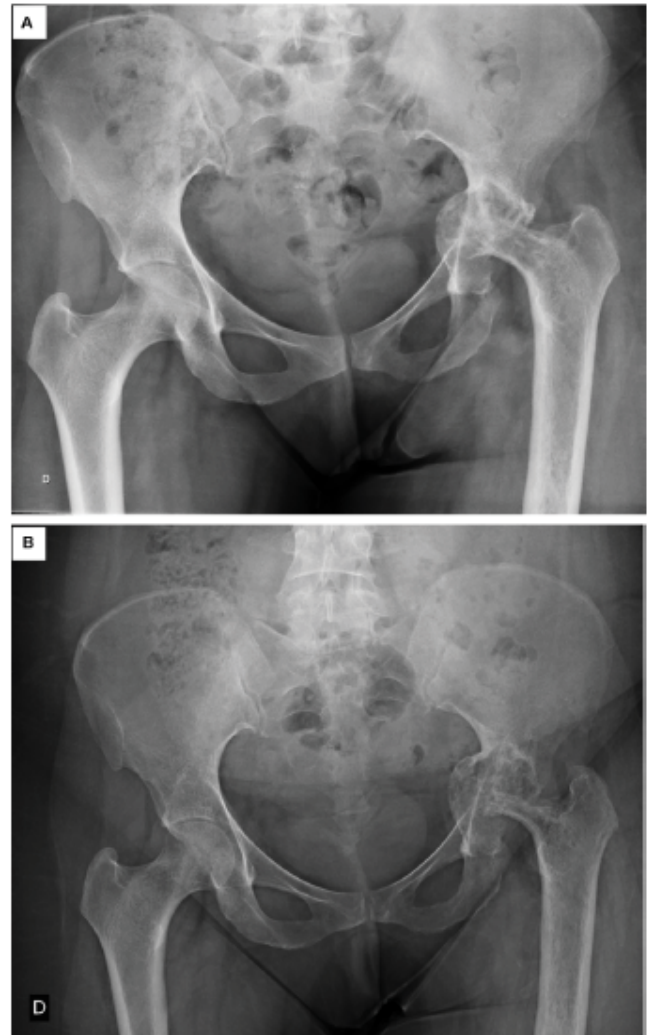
radiographic progression of the left hip joint (A:2014, B: 2019).
